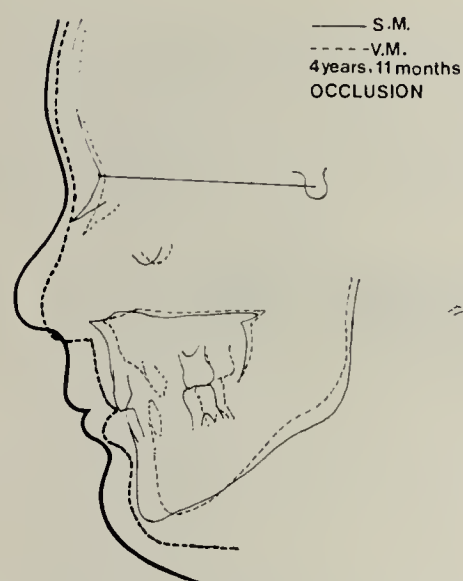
Lateral skull radiographs at 4 yr. 11 mth. superimposed on S-N.
